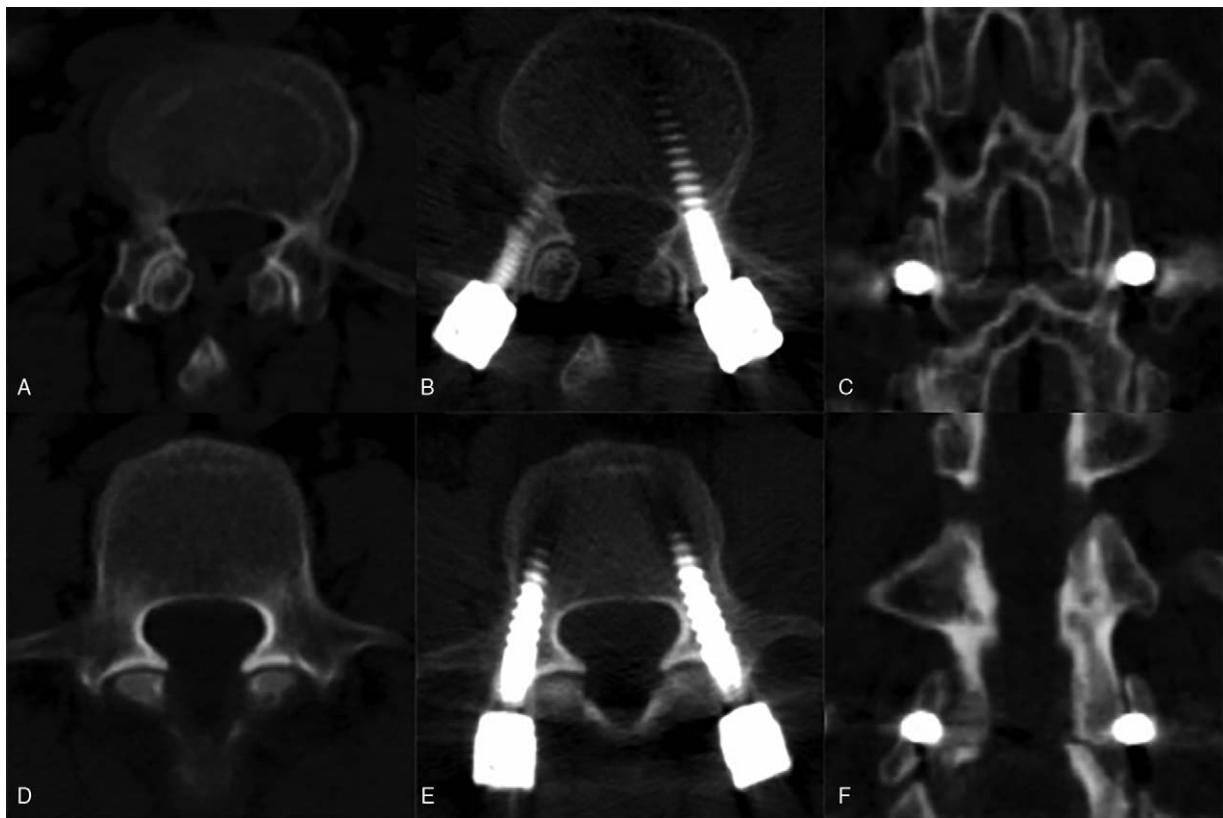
(A) Screw placement on the L4 vertebral body. The patient is a 62-year-old woman with grade I lumbar spondylolisthesis, who has undergone extreme lateral intervertebral fusion. The patient then received percutaneous pedicle screw fixation under anteroposterior-lateral C-arm fluoroscopy. The facet angle of L4 is 30 degree (left) and 29 degree (right). (B, C) The postoperative facet joint violation (FJV) grade was grade 0 bilaterally, whereas both computed tomography (CT) transverse section images and coronal reconstruction showed that no FJV. (E, F) Screw placement on the L4 vertebral body. The patient was a 57-year-old female with lumbar spinal stenosis who underwent extreme lateral intervertebral fusion. The patient then received percutaneous pedicle screw fixation, with L4 at the pedicle level and FAs of 68 degree (left) and 75 degree (right). Postoperative FJV was determined to be grade 2 (left) and grade 3 (right). CT transverse-sectional imaging and coronal reconstruction suggested that the pedicle screw has penetrated the joint cavity.
